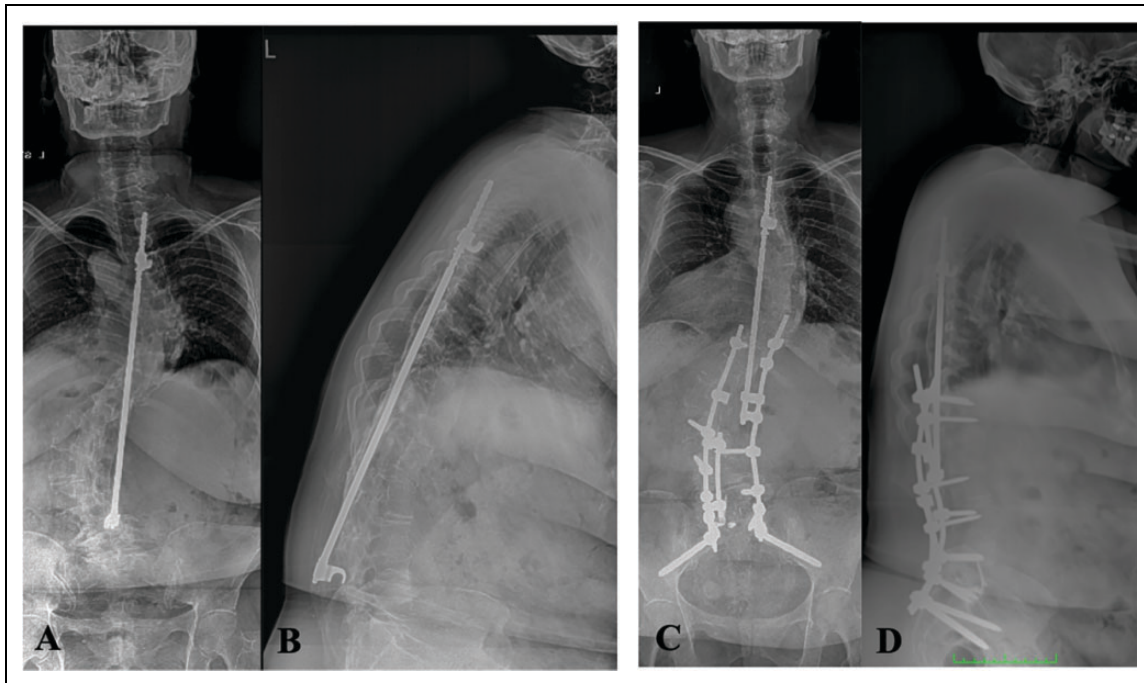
A 56-year-old female who presented with significant low back pain and bilateral buttock pain 40 years after her initial Harrington rod instrumentation for adolescent idiopathic scoliosis. Preoperative anteroposterior (AP) (A) and lateral plain radiographs (B) of the full spine reveal Harrington rod instrumentation with a caudal hook at L4 in the setting of positive sagittal balance and loss of lordosis. She subsequently underwent a staged procedure with a revision T10-pelvis posterior spinal fusion with an L5-S1 anterior lumbar interbody fusion performed in the initial stage, then a L4 pedicle subtraction osteotomy performed 6 days later (C, D) with restoration of her lumbar lordosis and improvement in her overall sagittal alignment.
